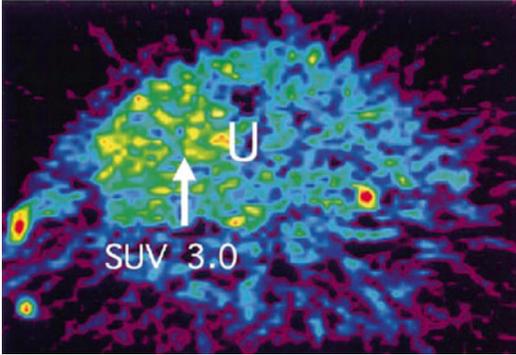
PET scan of leiomyosarcoma. With a Standard Uptake Volume (SUV) of 3.0 (white arrow) malignancy has become more likely [44] (With permission from Elsevier)
